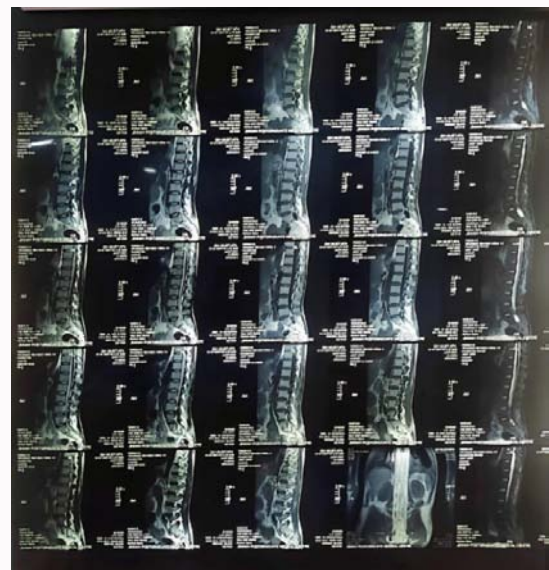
MRI lumbosacral spine and Hip showing avascular necrosis of hip joint.
